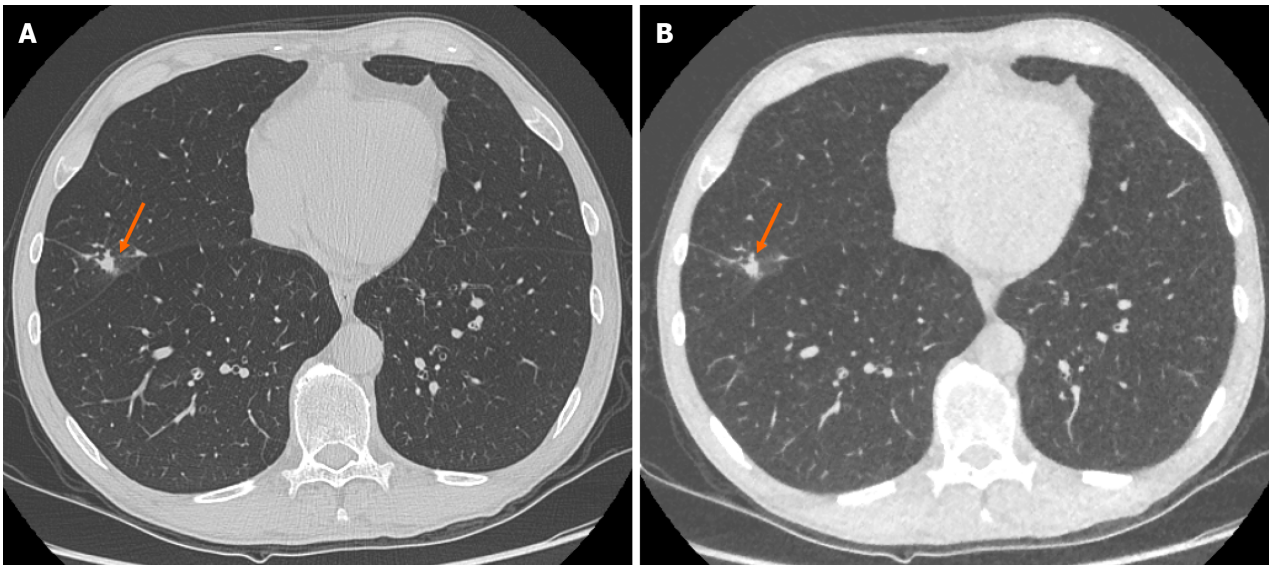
Representative images demonstrating image quality and ability to identify pulmonary nodules on both standard dose computed tomography chest and ultra-low-dose computed tomography chest with model-based iterative reconstruction imaging protocols. A: Selected axial slice of a standard dose computed tomography (CT) chest presented in lung windows with a solid pulmonary nodule with spiculation and pleural tethering in the lateral segment of the middle lobe (arrow); B: Selected axial slice of an ultra-low dose CT chest in the same patient at the same level presented in lung windows with the same correctly identified pulmonary nodule in the middle lobe (arrow). These images demonstrate the ability of ultra-low-dose CT chest with model-based iterative reconstruction to adequately maintain diagnostic accuracy with regard to solid pulmonary nodules.
